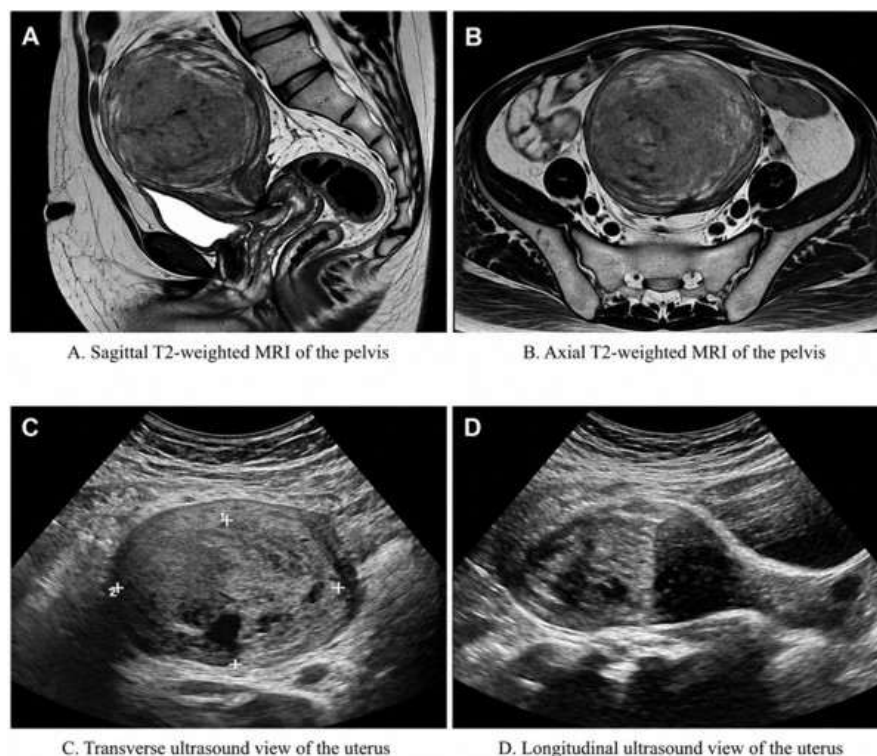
Preoperative pelvic imaging before hysterectomy. (A) Sagittal T2-weighted MRI of the pelvis. (B) Axial T2-weighted MRI of the pelvis. (C) Transverse ultrasound view of the uterus. (D) Longitudinal ultrasound view of the uterus.
